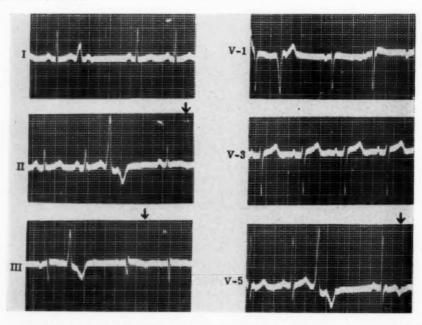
Elevation of the RS-T segments as well as inversion of the T waves in the sinus beats following ventricular extrasystoles in a 54-year-old woman who had hypertension and evidence of cardiac enlargement on x-ray. After the ventricular extrasystoles in Leads II and III, slight elevation of the RS-T segment and inversion of the T waves are noted. In Lead  $V_5$ , frank inversion of the T wave occurs in the sinus beat following the extrasystole. Other than the changes mentioned, this would be classed as a normal tracing.
